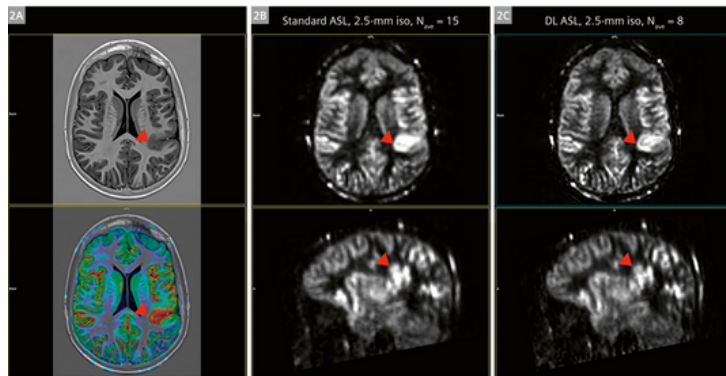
Case of epilepsy (15-year-old male). The left parietal lobe's focal cortical dysplasia is indicated by red arrows, which also show elevated perfusion activity during the MRI. Panel (2A) shows the high-resolution 2D T1-weighted TIRM image (top) and the overlaid perfusion map (bottom). Panel (2B) shows the acquired 2.5-mm isotropic mean perfusion-weighted map in both axial (top) and sagittal (bottom) views. Panel (2C) shows the reconstructed 2.5-mm isotropic mean perfusion-weighted map after applying DL algorithms and averaged
